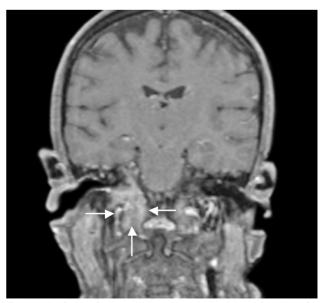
Coronal magnetic resonance imaging showing the infiltration of the right petrous apex and the right half of the clivus (arrows).
